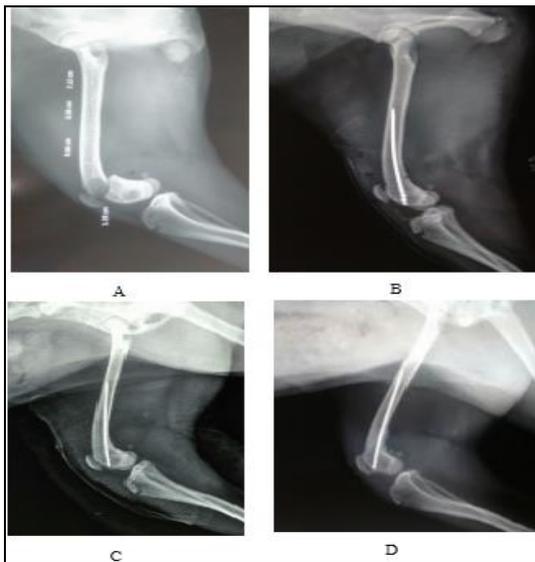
Progressive radiographic changes on the day before surgery (A), 1st (B), 15th (C) and 45th (D) post-operative days
